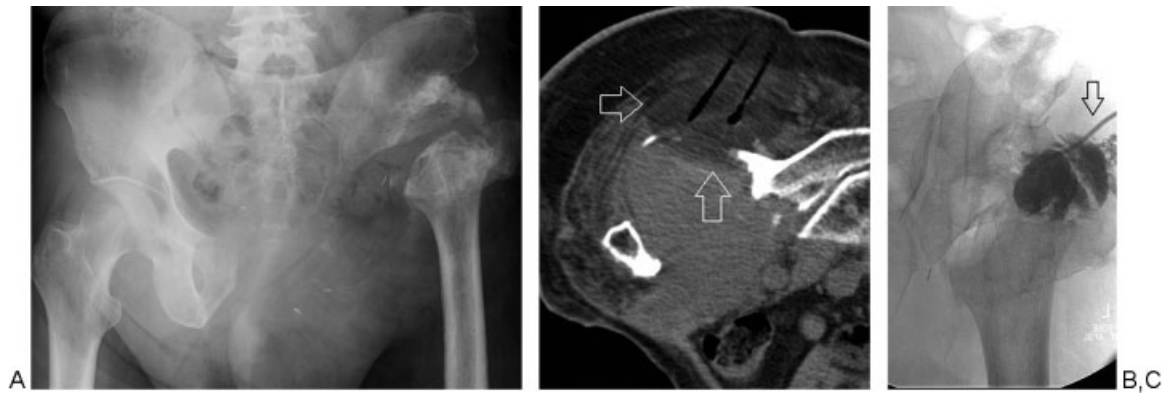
(A) A 60-year-old man with previous hemipelvectomy for large chondrosarcoma. Biopsy-proven recurrence near pseudoarticulation with large mucoid component. (B) Prone CT post-cryoablation depicts ice zone (arrows) after probe removal. Four probes were placed due to the large tumor size. (C) Two weeks later, the patient developed staphylococcal abscess at the treatment site requiring catheter drainage for an extended period. Contrast sinogram via pigtail catheter (arrow) shows residual cavity. CT, computed tomography.
